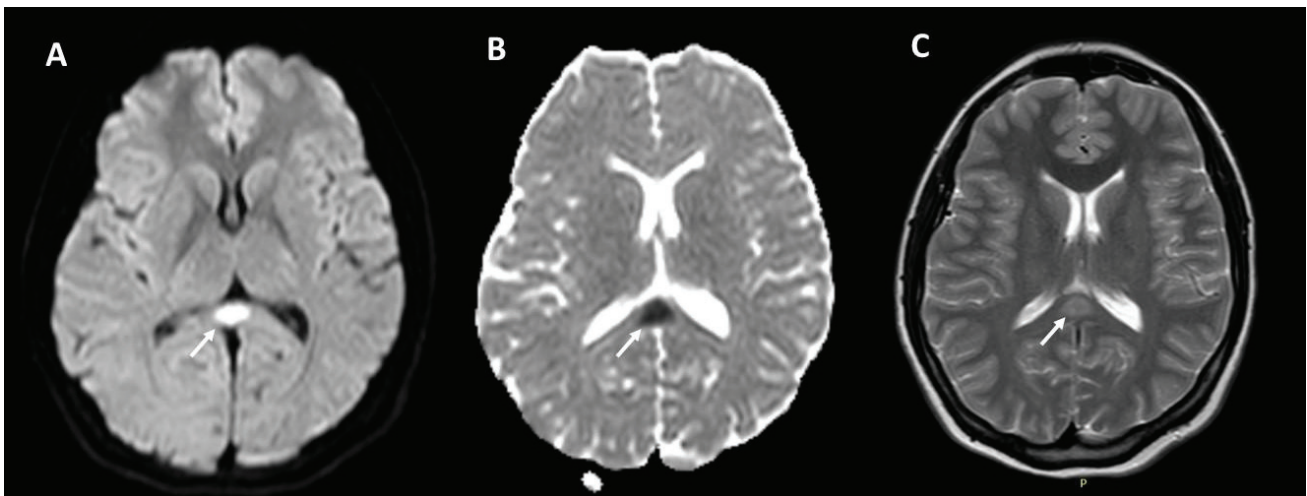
The Cranial MRI, performed at admission, showing the diffusion restricted lesion (A; DWI sequence, B; ADC sequence, C; T2-weighted sequence).
